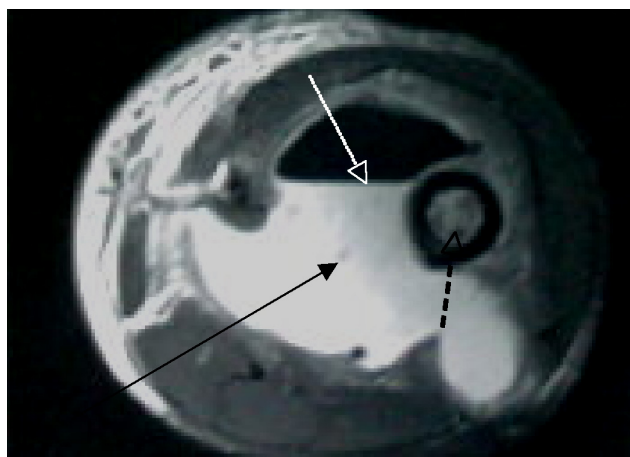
Axial magnetic resonance imaging of right thigh shows large abscess (arrow), air-fluid level (dotted white arrow), and gas in medulla (dotted black arrow).
